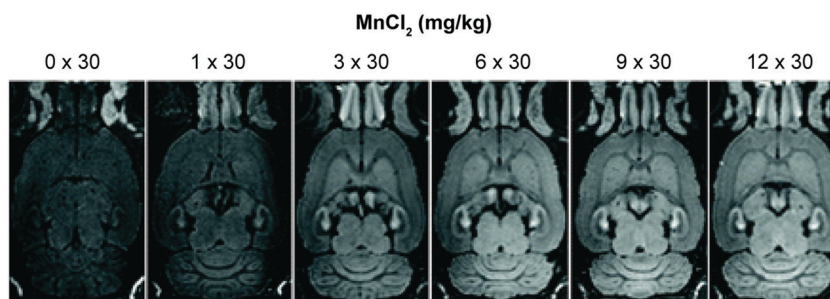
Example of manganese-enhanced MRI (MEMRI), showing an increased signal intensity throughout the brain with increasing concentration of  $\text{MnCl}_2$ . Reprinted (adapted) with permission from (*Schizophr. Bull.*, 2008, 34, 595–604). Copyright (2019) Oxford University Press.
